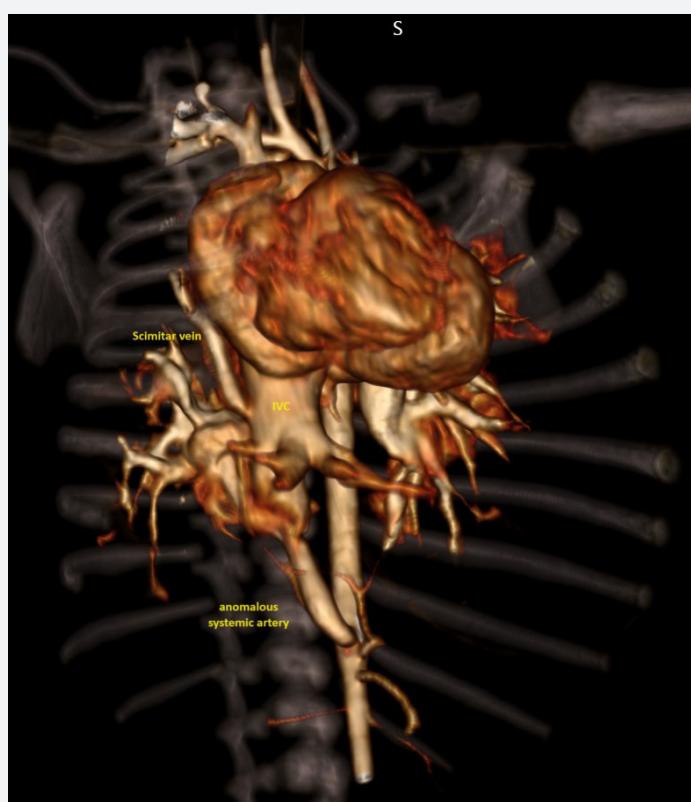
CT finding of our patient pointer out anomalous systemic supply to the right lower lung lobe from the abdominal aorta (pseudo sequester), partial anomalous vein return of two right pulmonary veins, which drained to the suprahepatic part of the inferior vena cava.
